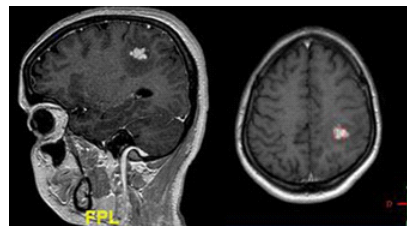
T2 weighted image of MRI Brain Heterogenous lesion in left parietal region
